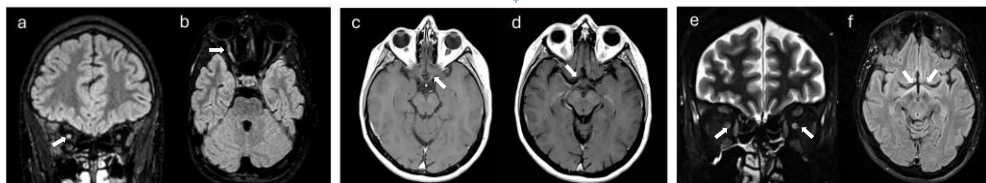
MRI abnormalities of the optic pathways in the three patients with LHON. (a, b) Patient 1: coronal and axial FLAIR images show hyperintensity of the right optic nerve. (c, d) Patient 2: post-contrast T1-weighted images show mild enhancement and enlargement of the intracranial segment of the left optic nerve (c) and of the right hemichiasm and optic tract (d); (e, f) Patient 3: coronal T2-weighted fat-suppressed image shows bilateral hyperintensity in the retrobulbar segments of the optic nerves (e), with additional bilateral involvement of the optic tracts on FLAIR sequences on follow-up MRI (f).
